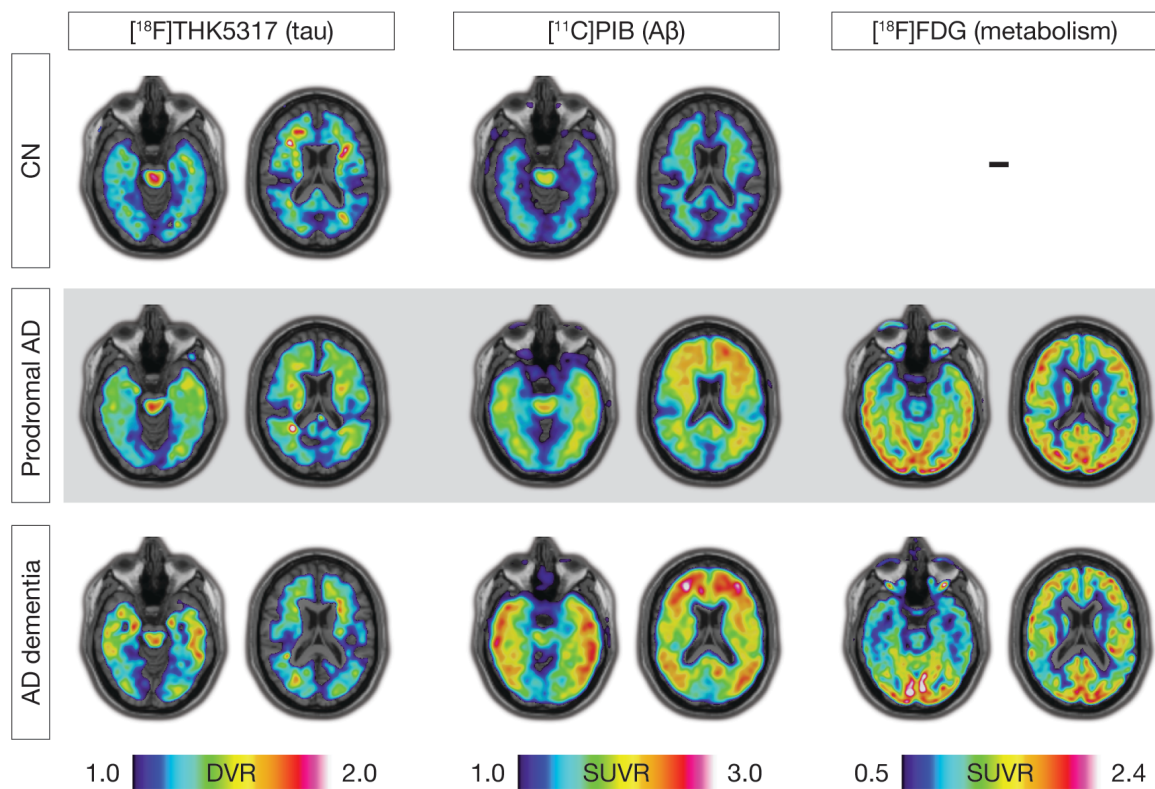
Sample $[^{18}\text{F}]\text{THK5317}$ DVR, $[^{11}\text{C}]\text{PIB}$ SUVR and $[^{18}\text{F}]\text{FDG}$ SUVR images from an elderly cognitively normal (CN) volunteer, a patient with prodromal AD and a patient with AD dementia. Cerebellar grey-matter was used as a reference region for $[^{18}\text{F}]\text{THK5317}$ and $[^{11}\text{C}]\text{PIB}$, and the pons was used for $[^{18}\text{F}]\text{FDG}$.
